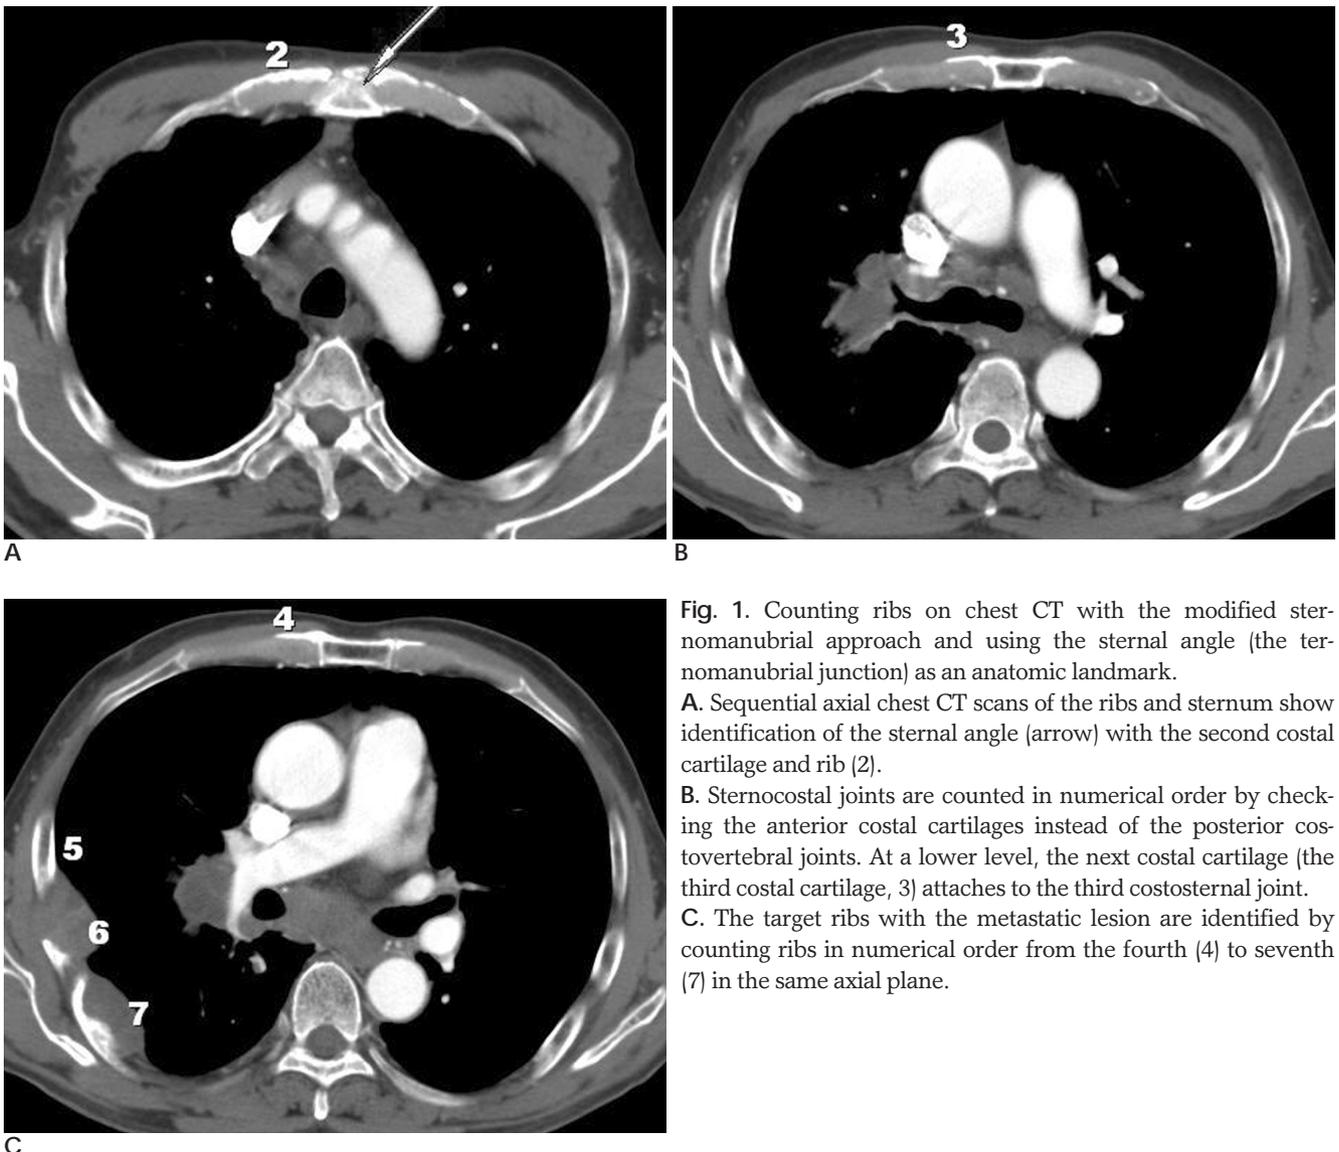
Counting ribs on chest CT with the modified sternomanubrial approach and using the sternal angle (the sternomanubrial junction) as an anatomic landmark.
